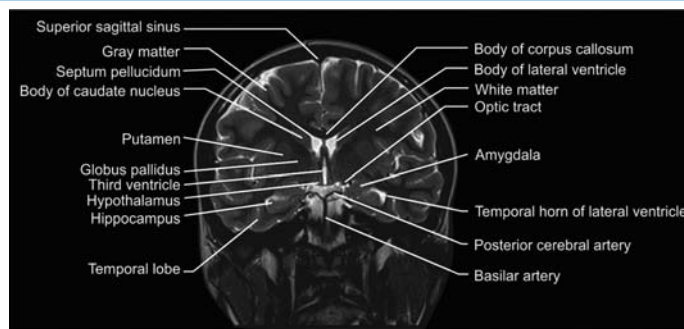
MRI Coronal view of brain
